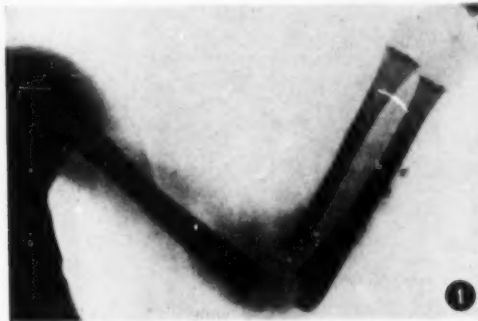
X-ray of left upper limb showing periostitis of humerus and osteochondritis of lower end of ulna (Case 1).
